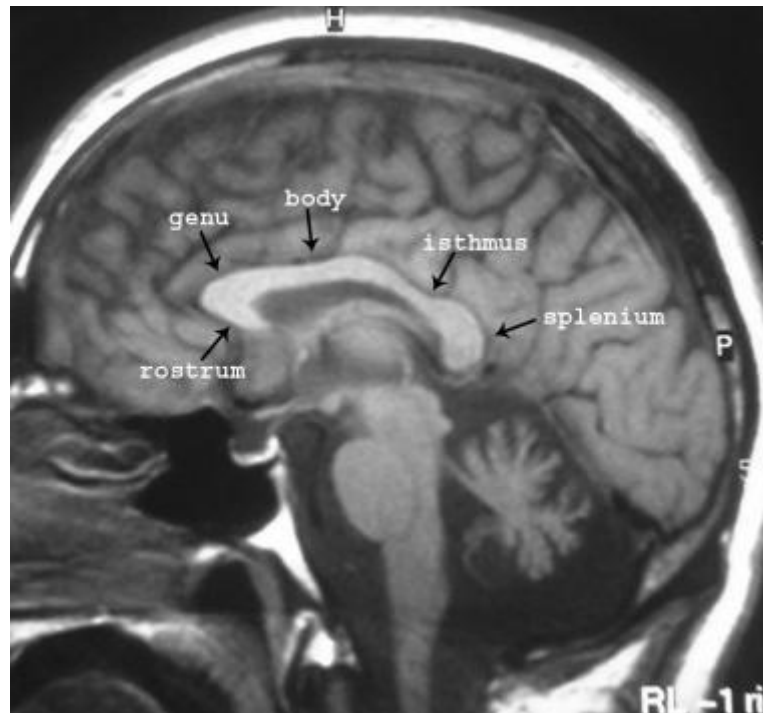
MRI Image showing parts of corpus callosum
